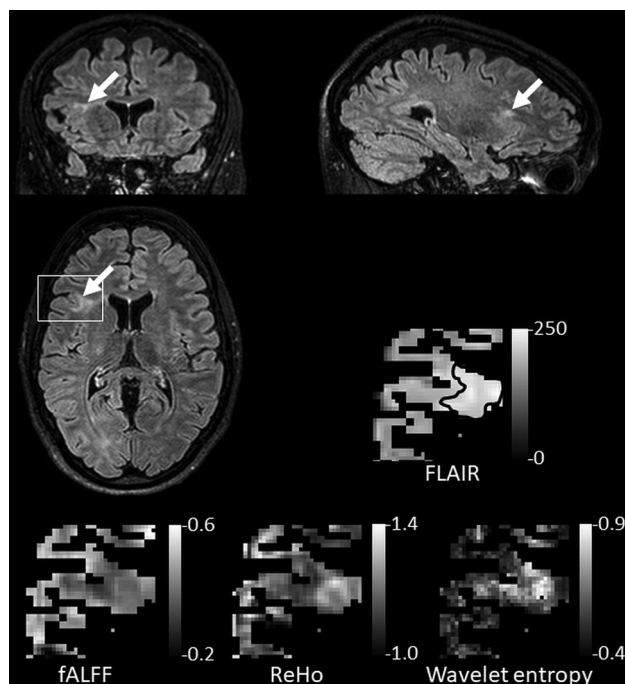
Sample orthogonal FLAIR images depicting an FCD lesion (arrows) of a 30-year-old woman. Inserts show the magnification of the lesion on FLAIR contrast and cortical parameter maps of fALFF, regional homogeneity, and wavelet entropy. Increased regional homogeneity, wavelet entropy, and decreased fALFF were observed in the FCD lesion and the immediate perilesional regions in comparison with the regions more distinct from the FCD. Only gray matter is visualized; white matter is masked out.
